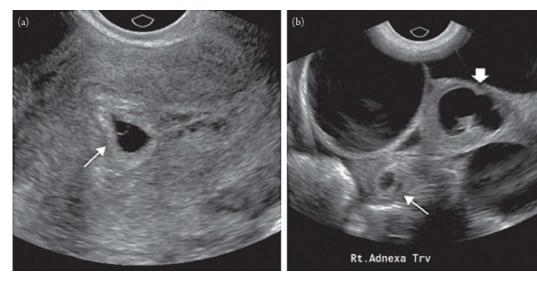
Adapted from Figures 32.7 and 32.12 of Scoutt LM, Hamper UM, Angtuaco L, eds. *Ultrasound*. Oxford, UK: Oxford University Press: 2017.
